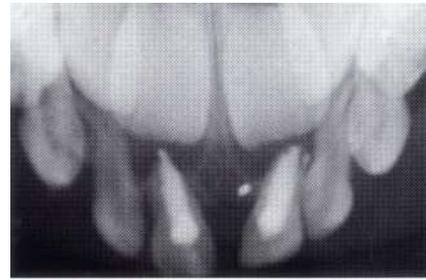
Completed x-rays of primary incisors that were nonvital because of trauma and required pulpectomies.
